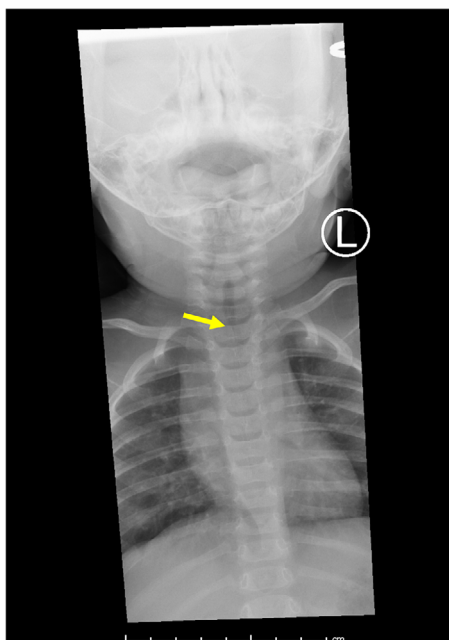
Chest radiograph demonstrating limited view of the narrowed air column (yellow arrow) past the thoracic inlet
